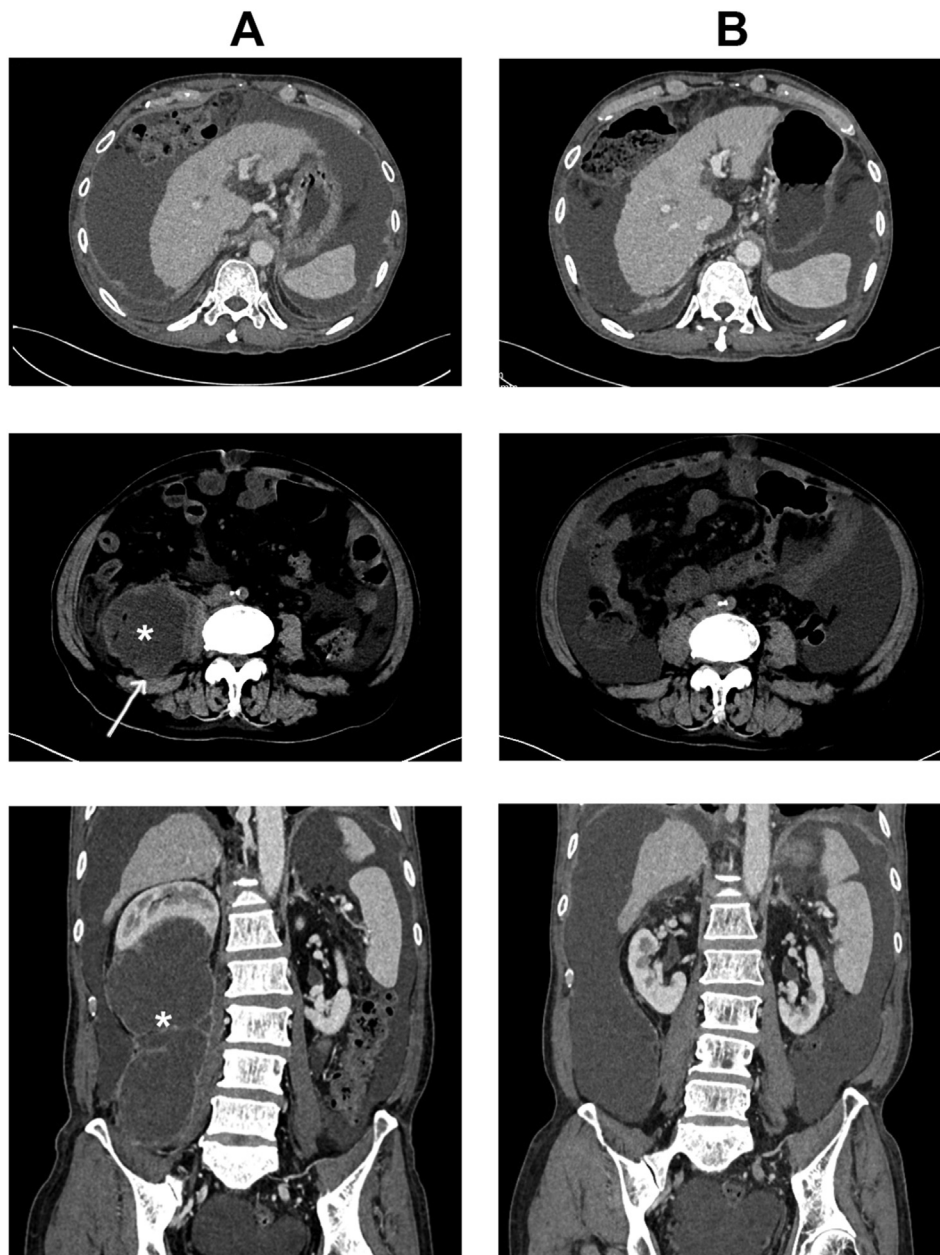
CT scan of the abdomen. A. Upper panel: liver cirrhosis, large amount of ascites was shown. The lesion in the area of the right kidney was shown in the axial sections (middle panel) and coronal sections (lower panel) of the CT scan. The lesion is marked by *. The arrow indicates the drainage path. B. CT follow-up of the abdomen two months after the patient was discharged.
